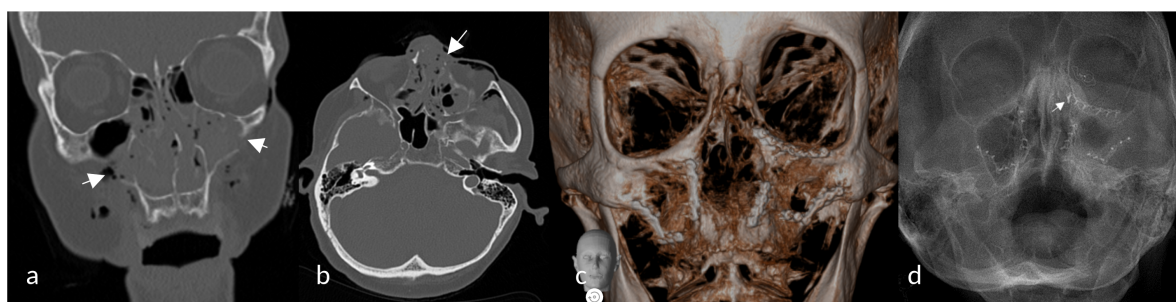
Fracture along the Lefort-I plane (a) and the left nasoorbitoethmoideal complex (b); initial osteosynthesis using miniplates along the midfacial pillars and along the left infraorbital rim (c) and postreconstructive radiographic control of graft placement (d).
